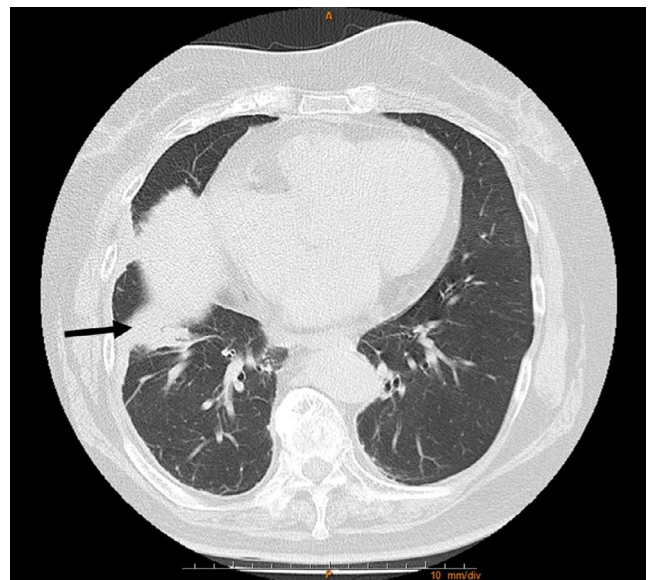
A computed tomography image of the chest. An arrow indicates infiltration in the middle and lower lobes of the right lung with an adjacent pleural thickening and a small amount of pleural effusion
